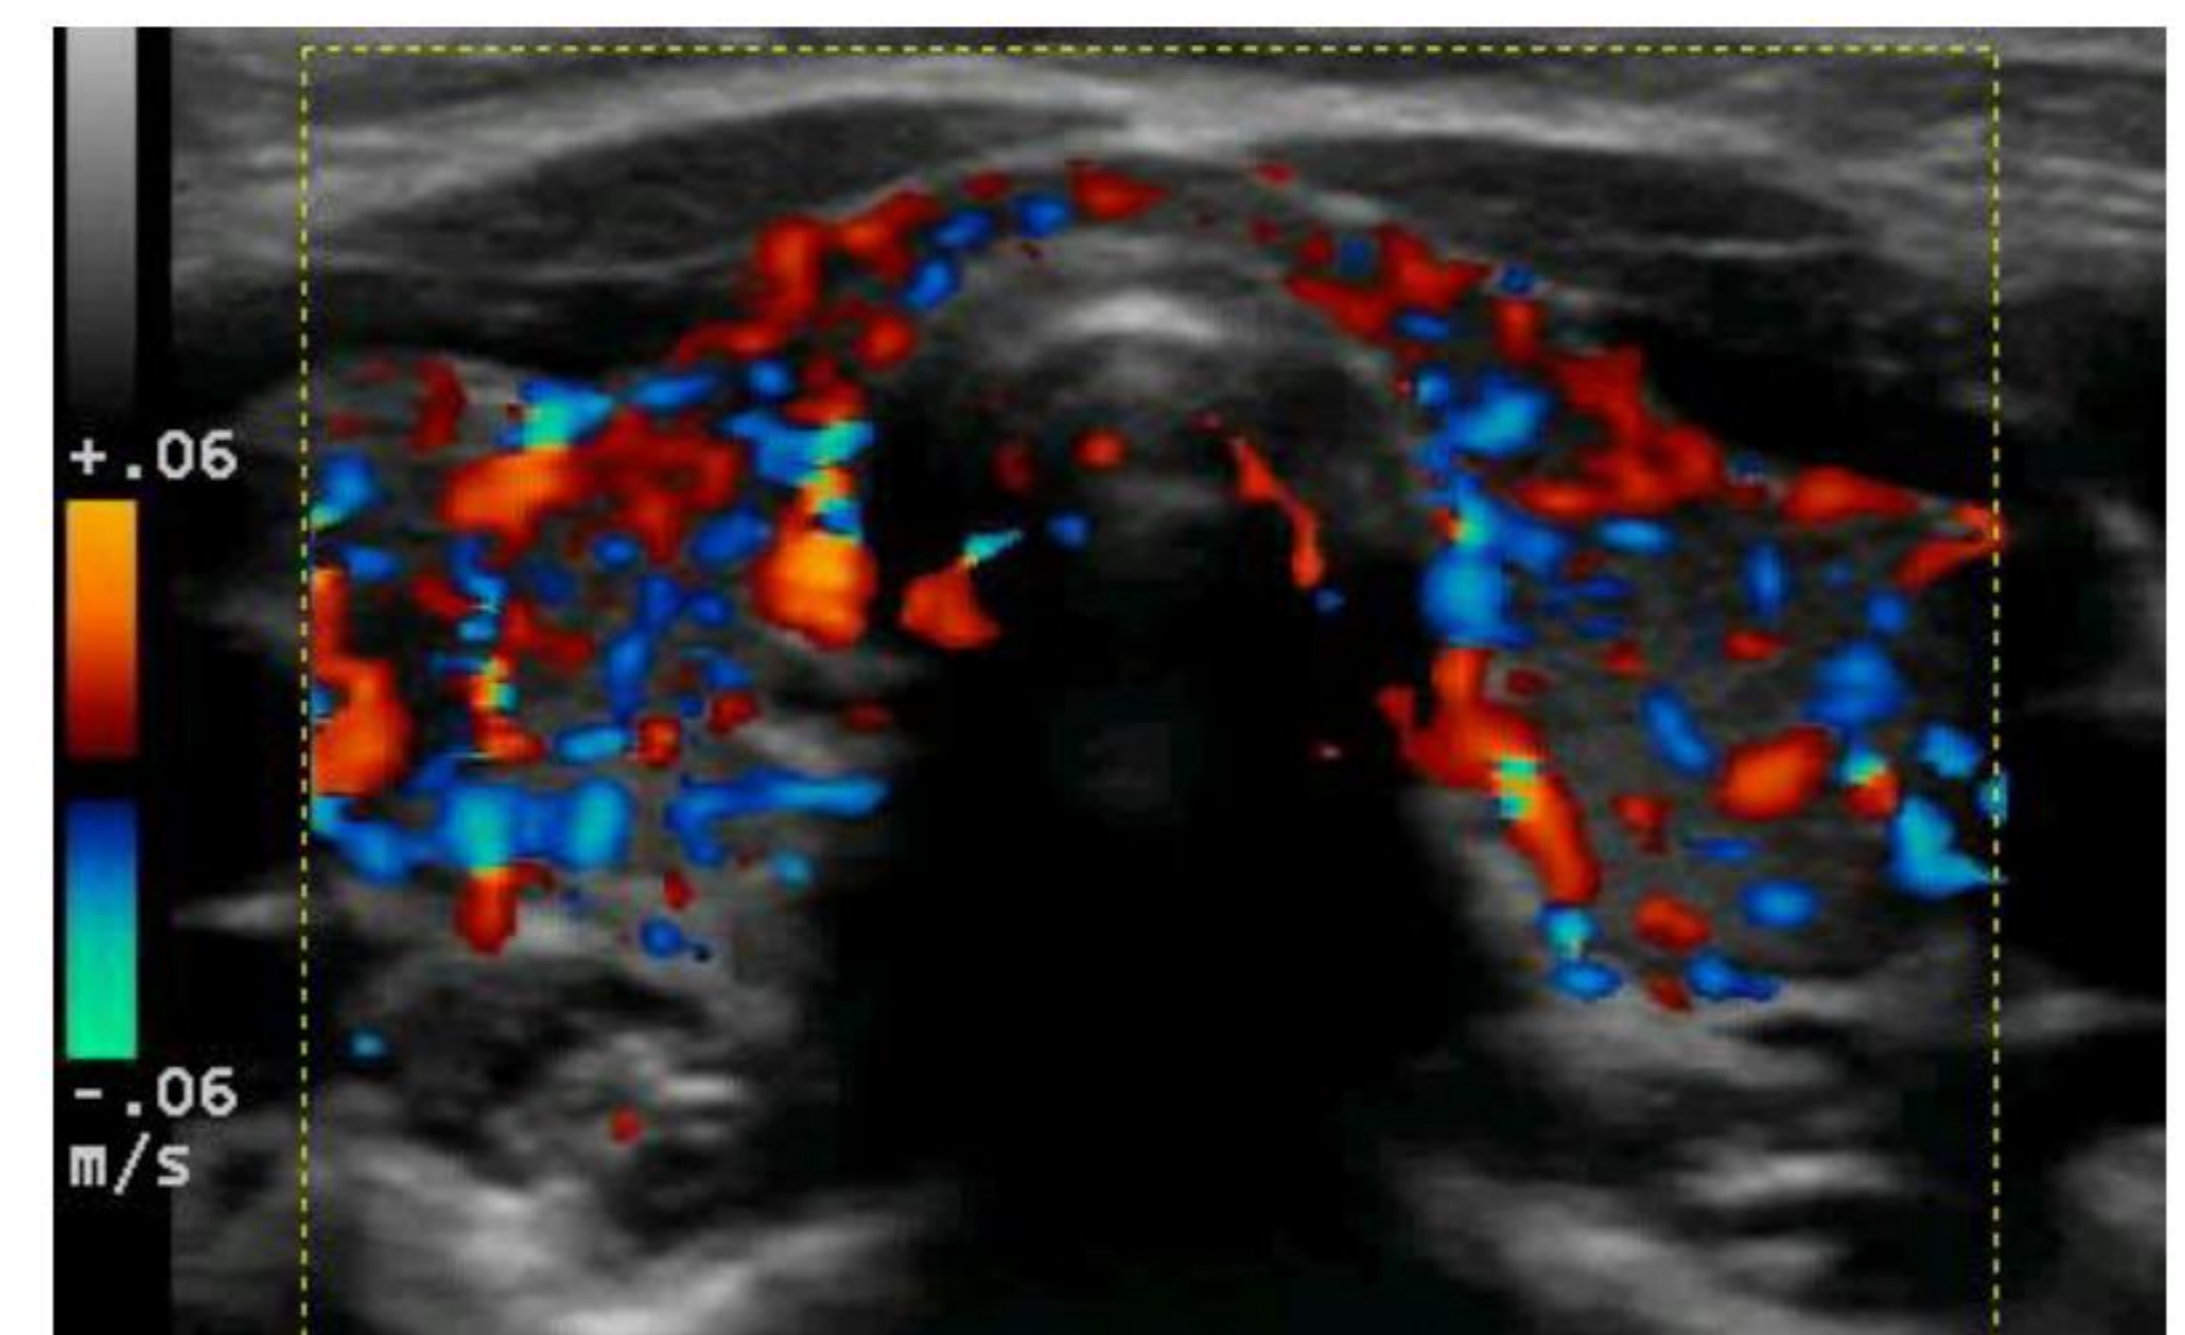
Color-doppler and Power-doppler images show gland hypervascularity
